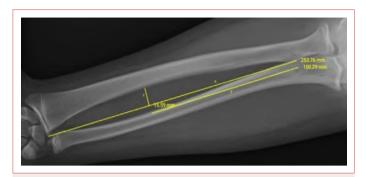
Measurement method for radial bowing and the location of maximum bowing as per the method described by Firl and Wünsch (2004).^[3] The radial bowing (r/x) was calculated by measuring the maximum perpendicular distance (r) from the shaft of the radius to a straight line (x) drawn from the radial head to the radial styloid process on an anteroposterior radiograph. The bowing location (y/x) was defined as the distance (y) from the proximal radial end to the point of maximal bowing, divided by the total radial length (x).
